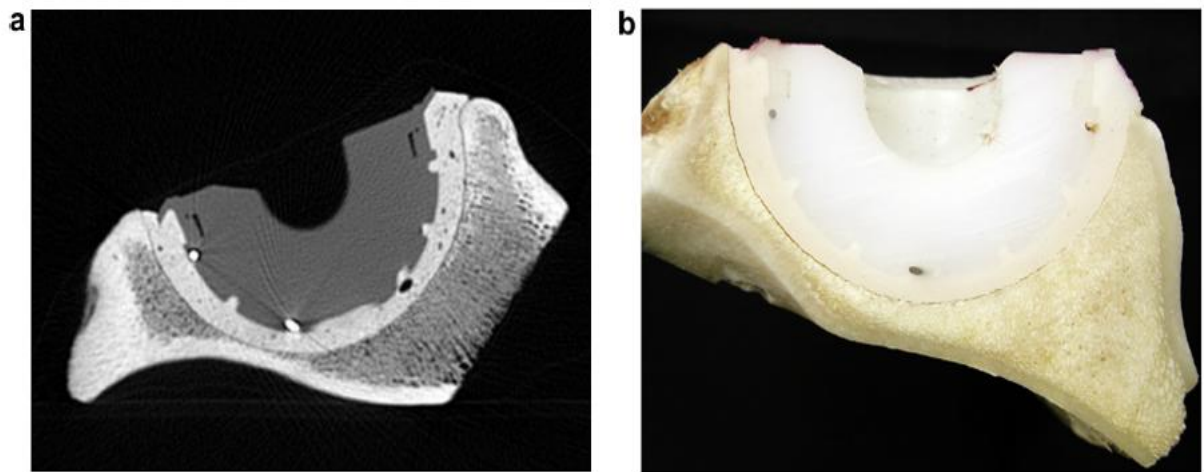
20: Debonding at the bone-cement interface of a sample tested under descending stairs loading condition. (a) A CT scan image showing clear demarcation at the bone-cement interface; (b) almost complete separation of the bone-cement interface (Tong et al., 2008).
